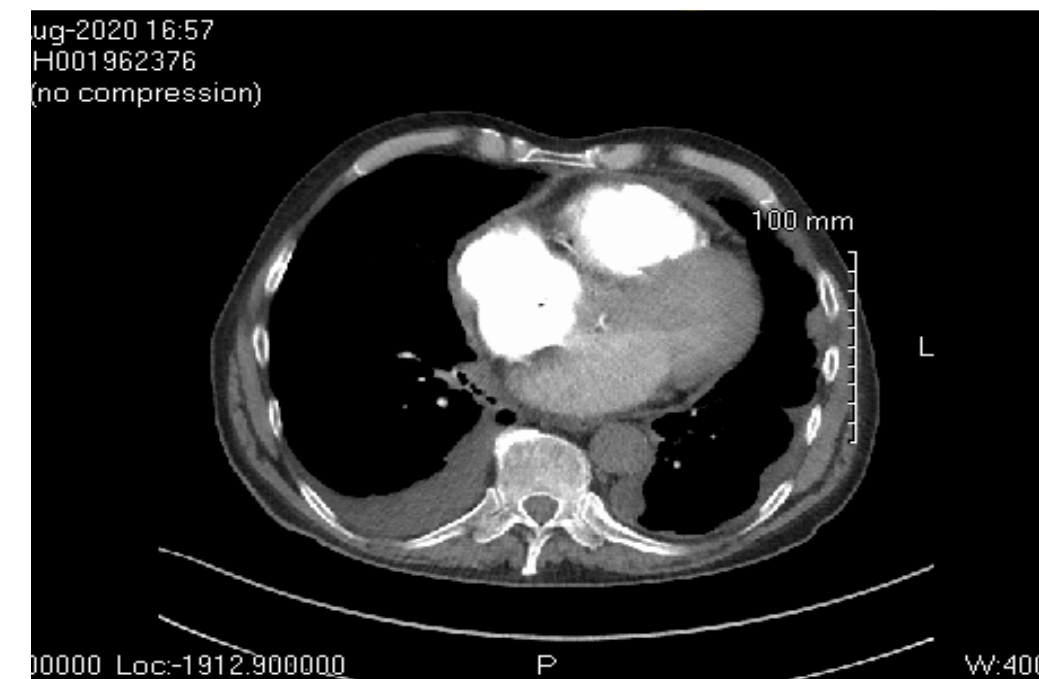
CT scan of the thorax on day 4 of the second admission showing pleural effusions and no pulmonary emboli or interstitial pathology.
